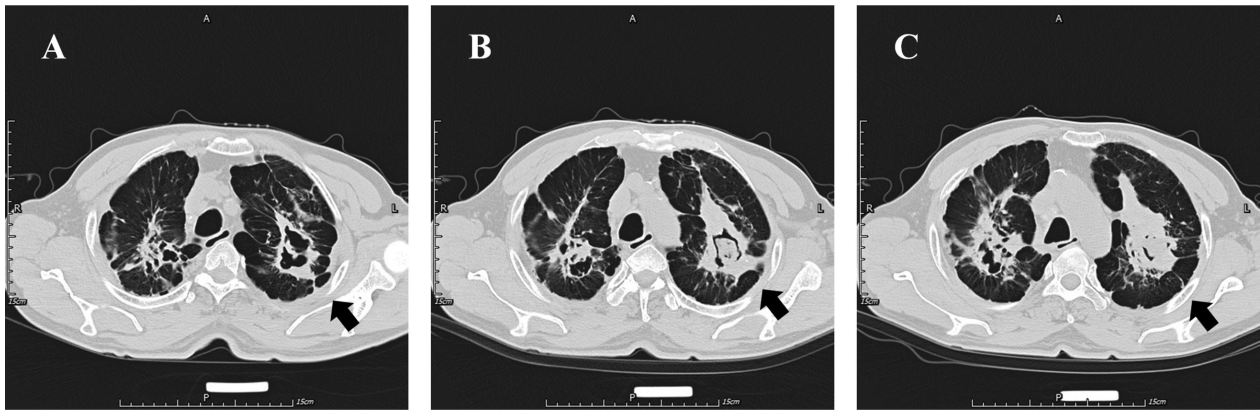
(A–C) CT of the thorax before treatment showed cavity with spherical mass consolidation-aspergilloma (black arrow) in the left upper lobe apical segment and multiple cystic cavities in the right upper lobe apical segment.
